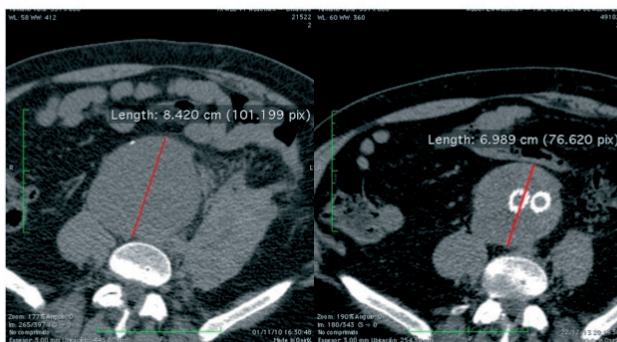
Computed tomography angiography before the intervention (left) and at 2-year follow-up (right) showing reduction of the aneurysmal sac.
